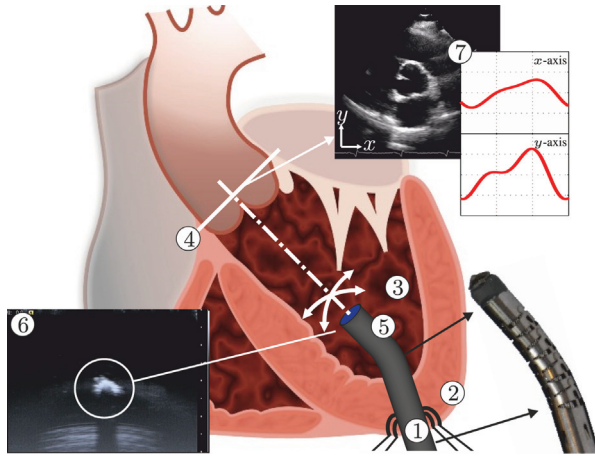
Model predictive control (MPC) can be used to steer the robotically actuated delivery sheath (RADS) in order to assist the clinician during cardiovascular surgery. The potential of MPC in cardiovascular surgery can be demonstrated by compensating for the aortic heart valve (AHV) motion in a representative case of transapical transcatheter aortic valve implantation. The RADS ① is inserted through the apex ② into the left ventricle ③ and oriented towards to the aortic annulus ④. The articulating tip ⑤ of the RADS can be steered inside the left ventricle under ultrasound ⑥ image guidance in two degrees of freedom by two pairs of antagonistically configured tension wires. Pre-operative ultrasound data ⑦ can be used as an input to the MPC strategy to anticipate and compensate the AHV motion during surgery.
